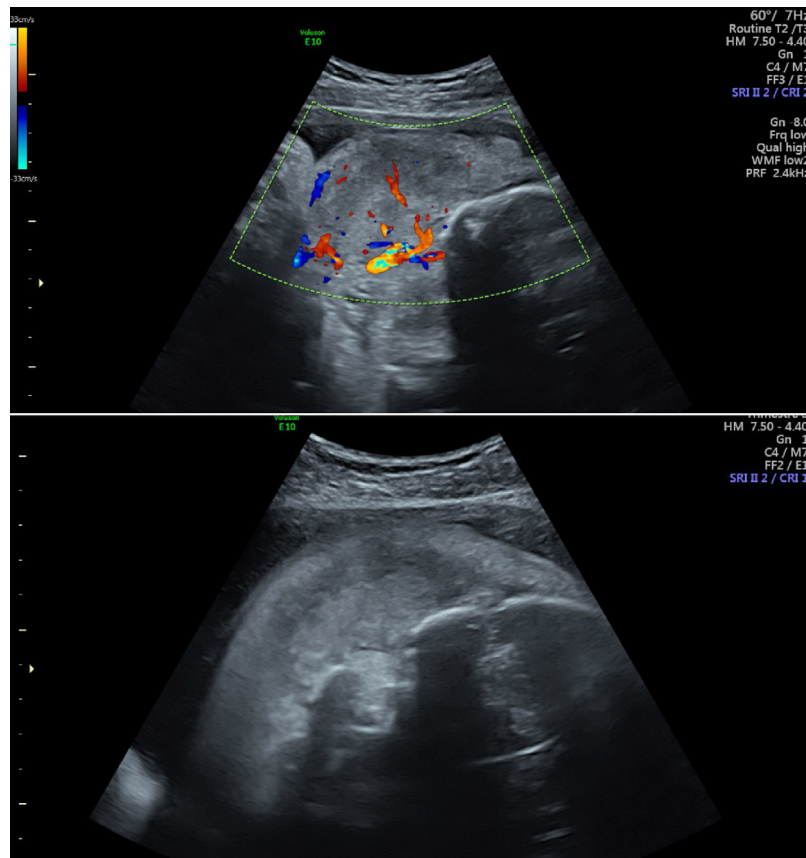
Prenatal ultrasound of the vascular tumor.
